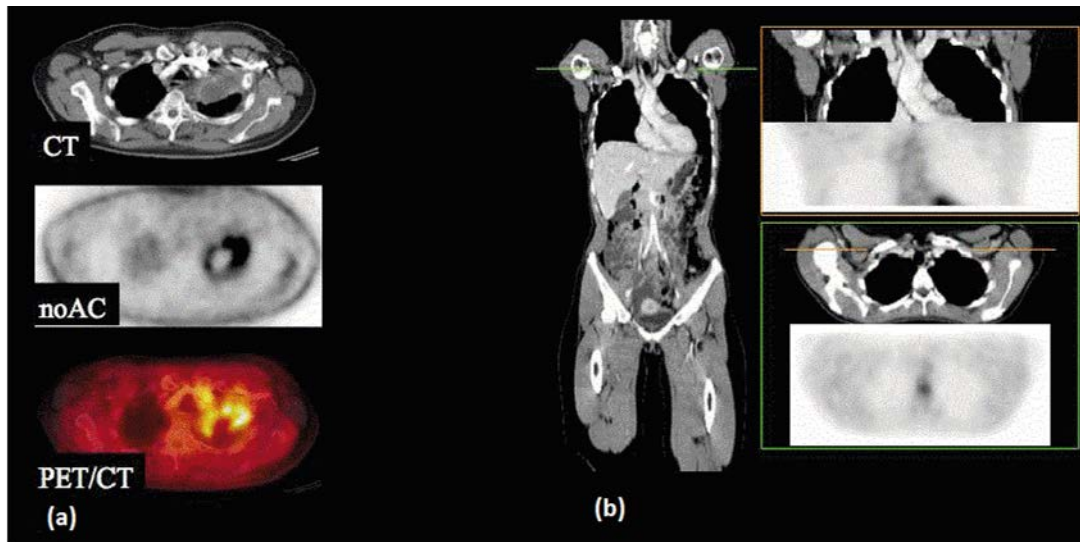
(a) Contrast enhanced CT, uncorrected PET, and PET/CT fusion using AC-PET data demonstrating a hot spot artefact from focal contrast accumulation in the subclavian vein. (b) The use of a modified intravenous contrast administration protocol can help to reduce contrast accumulation in the subclavian vein while providing generally good contrast enhancement. AC: attenuation corrected; noAC: not attenuation corrected.
